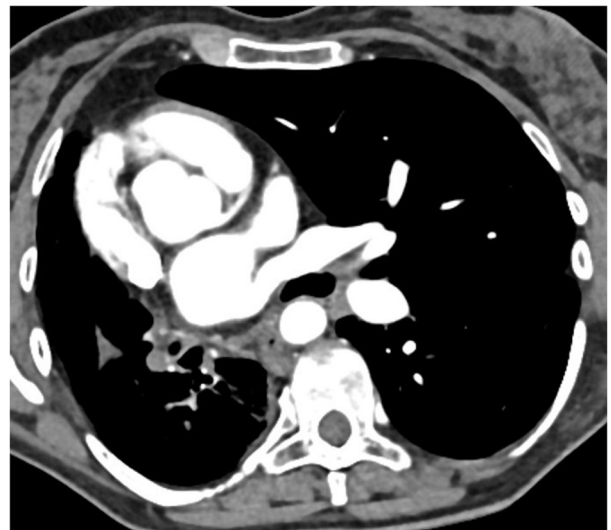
CT scan section obtained at the level of the left atrium in a patient with unilateral agenesis of pulmonary veins. Note the absence of pulmonary venous return at the level of the left atrium with no opacification of ipsilateral pulmonary arteries. Presence of small-sized vascular sections in the right hilum, suggestive of collateral vascular supply.
